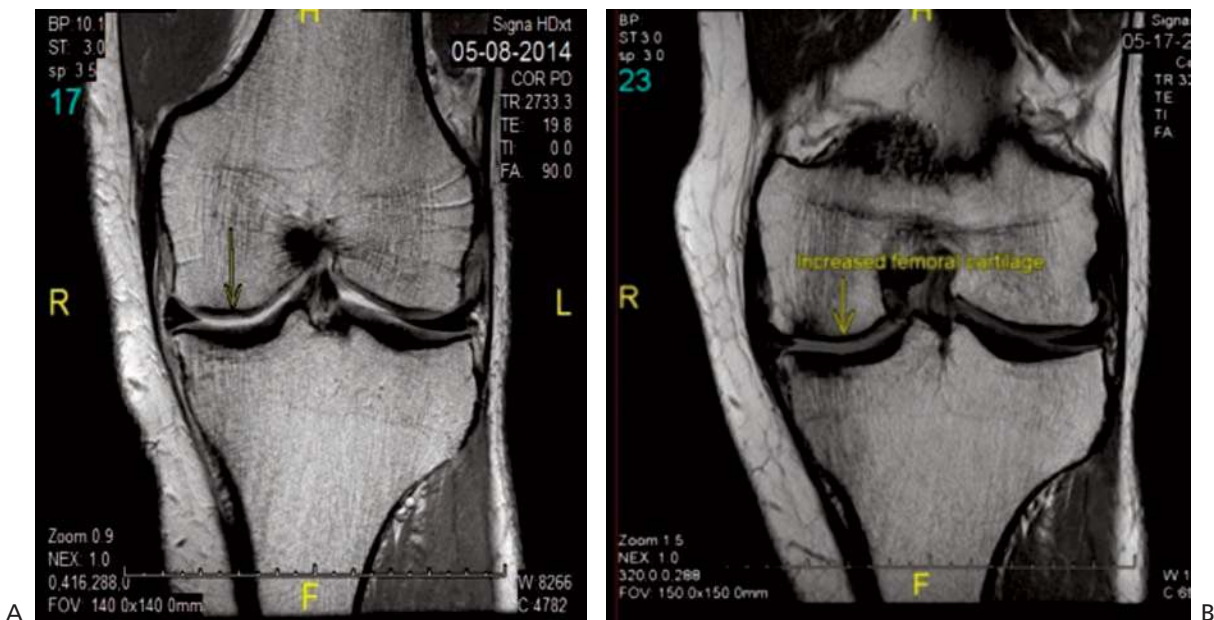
A, MRI prior to treatment revealing medial compartment degeneration (arrow). B, MRI 6 months after treatment with widening of the joint space and improved signal and thickness of the cartilaginous tissue (yellow arrow). MRI prior to treatment reveals a thinning articular cartilage measured by Radiologist to be 0.75 mm. MRI taken 6 months post treatment reveals an improved thickened articular cartilage measured by Radiologist at 1.5 mm of cartilage.
